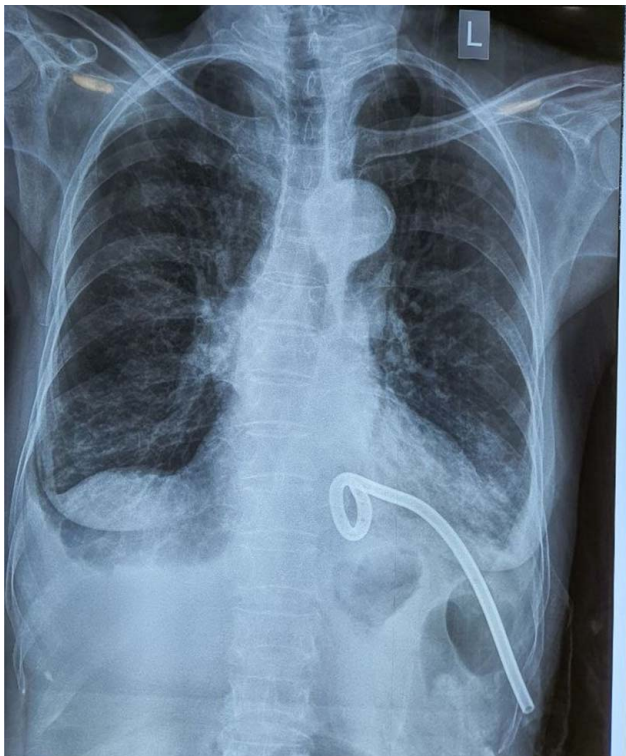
Serial Chest X-ray posteroanterior view day 2 showing empyema (resolving) under drainage with pigtail *in situ*.
